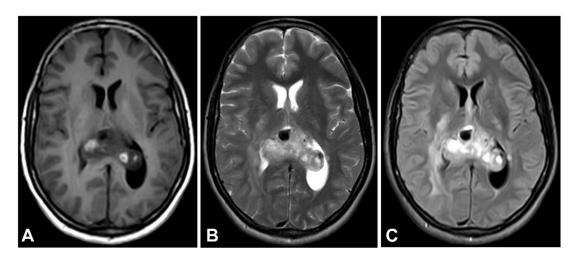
Axial T1 sections showing a heterogeneously hypointense lesion, and axial T2/FLAIR sections showing a heterogeneously hyperintense lesion.
